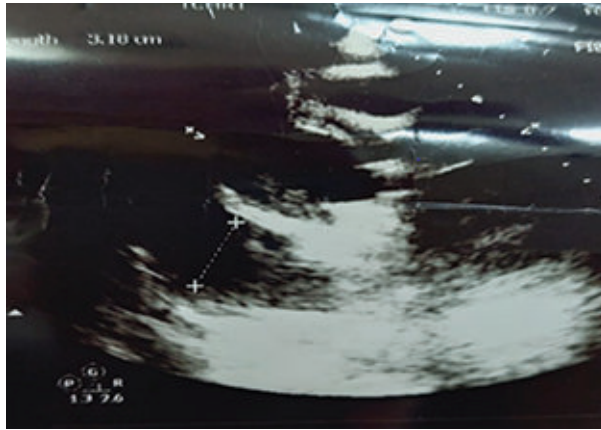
Preoperative Echocardiography show Massive Pericardial Effusion.
